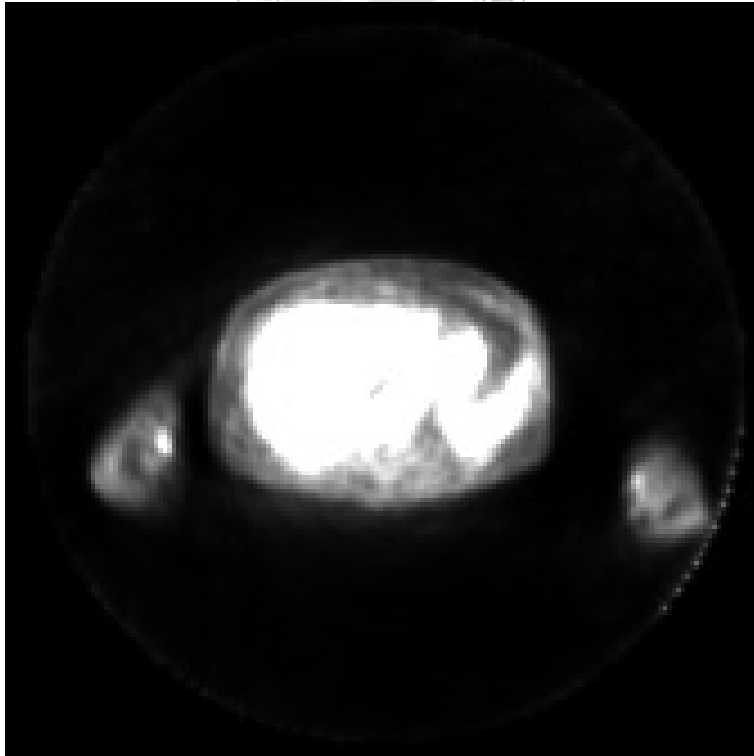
After SUV calculation, lots of air and non-body pixels have been removed.
